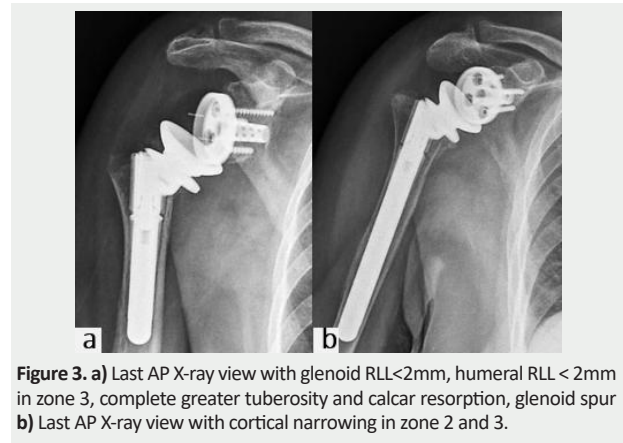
a) Last AP X-ray view with glenoid RLL<2mm, humeral RLL < 2mm in zone 3, complete greater tuberosity and calcar resorption, glenoid spur b) Last AP X-ray view with cortical narrowing in zone 2 and 3.
